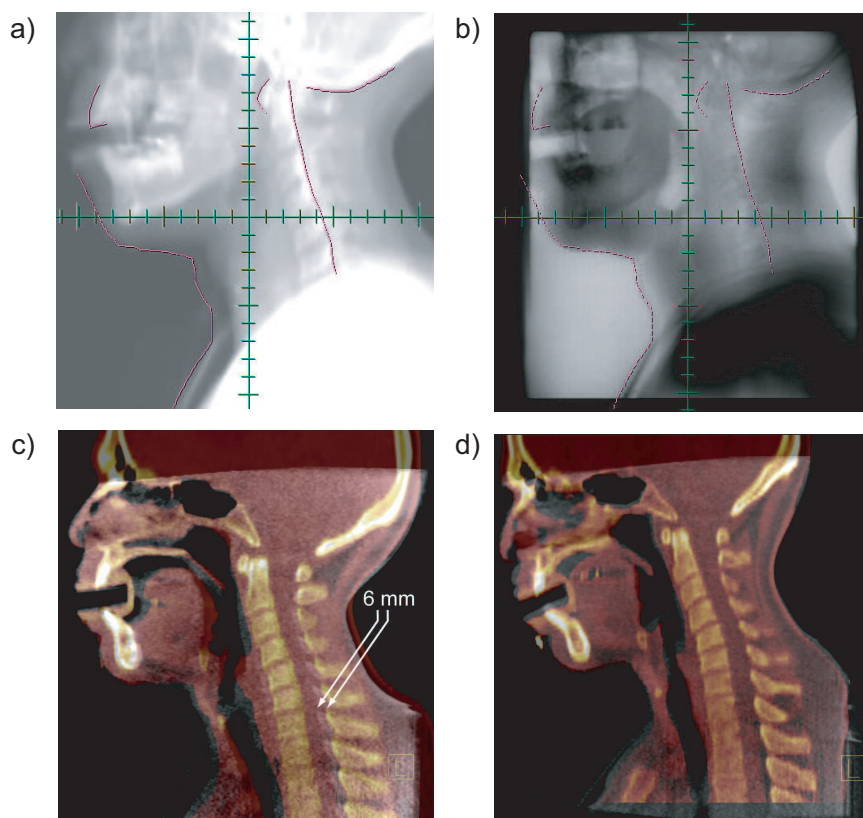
Assessment and correction of a complex neck distortion using MVCBCT. On the same day, a head and neck patient positioned with a TIMO C head holder was imaged using portal imaging (b) and MV CBCT (c). A difference in the arching of the neck is difficult to detect using the lateral digitally reconstructed radiograph (DRR) (a) overlaid on to the portal image (b). Registration of the patient MVCBCT (gray scale) with the kV CT (color) in (c) revealed a complex distortion of the lower neck region which creates a 6 mm misalignment of the vertebral bodies and spinal cord. A new MVCBCT (color) compared with the new CT (gray) in (d) showed improvement in the 3D alignment.
